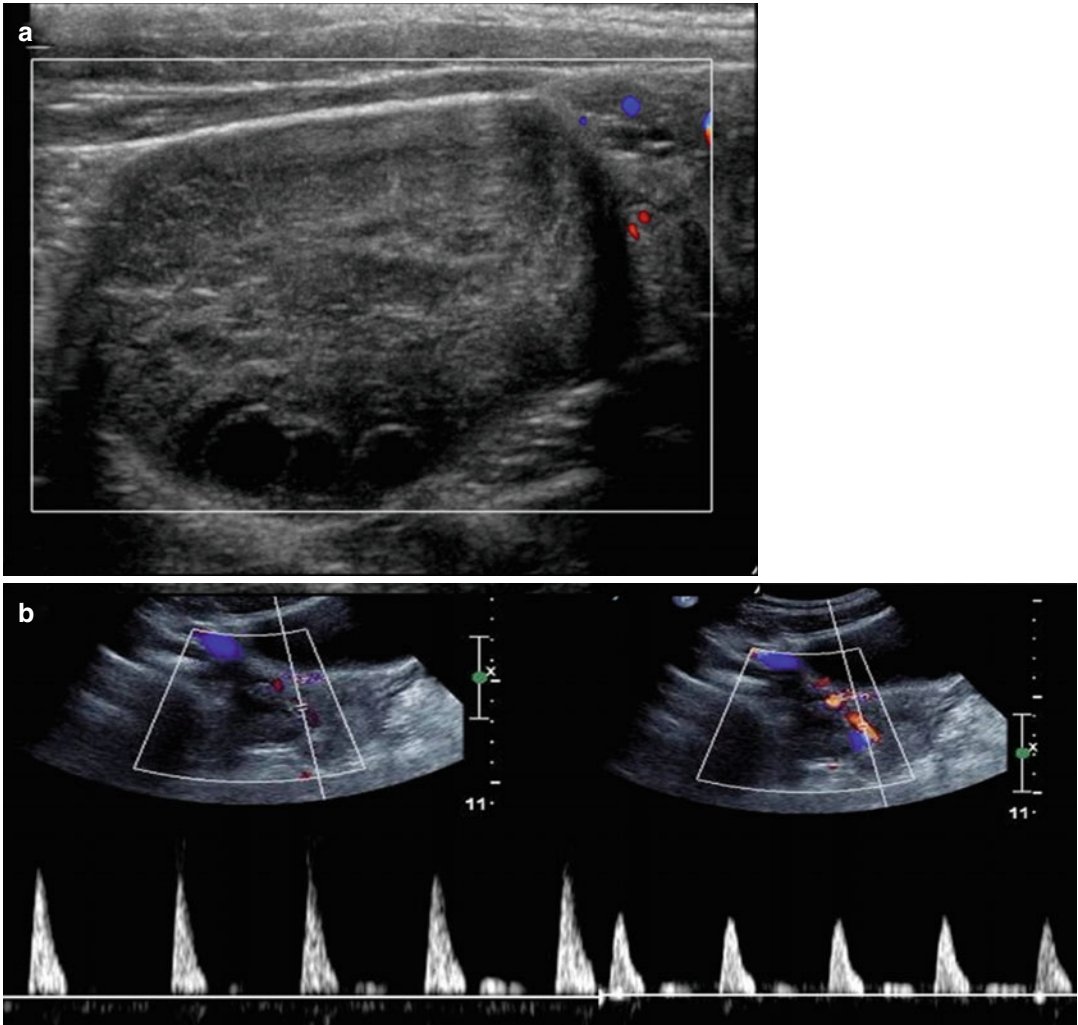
(a) The absence of color or spectral flow within an abnormal ovary is suggestive of torsion. (b) The use of Color Doppler in an enlarged ovary shows the absence of the end diastolic flow of arterial waveform
